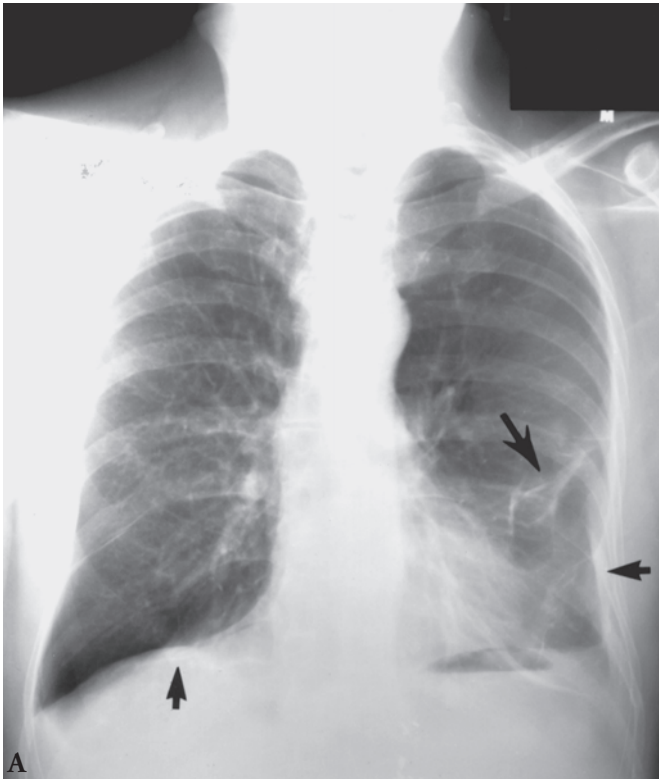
Abnormal CXR, *A*, in a 68-year-old asymptomatic man. *Small arrows* indicate areas of pleural calcification, particularly on the right hemidiaphragm. This is a tip-off to previous asbestos exposure. The process in the left mid lung was worrisome (*large arrow*), perhaps indicating a new process such as bronchogenic carcinoma in this smoker. However, CT, *B*, disclosed rounded atelectasis (*small arrow*). The “comma” extending from this mass is characteristic of rounded atelectasis, which is the result of subacute-to-chronic pleural effusion resolving and trapping some lung as it heals. Also note pleural calcification in *B* (*large arrow*).
